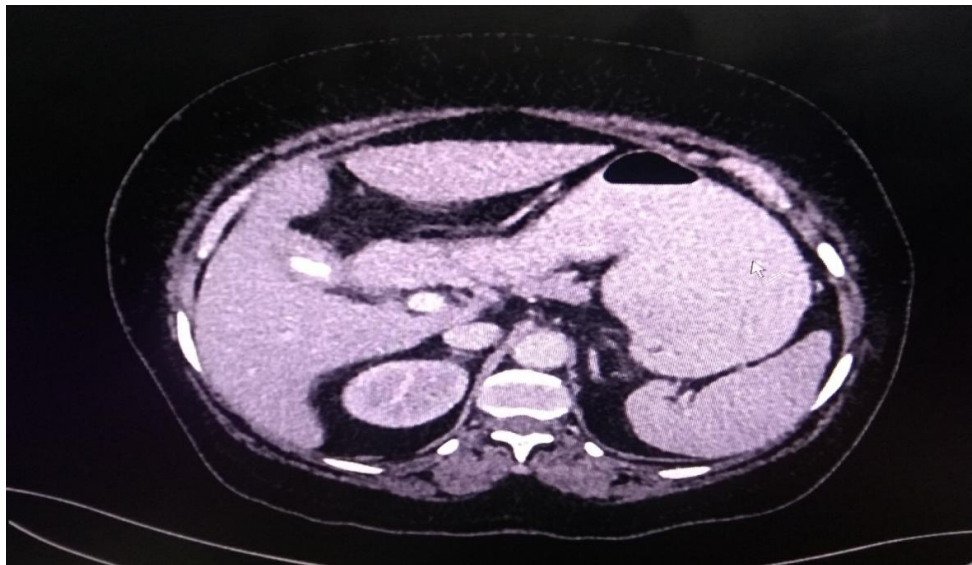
Computed tomography shows foreign body in gallbladder with air-foci and cholecystoduodenal fistula
